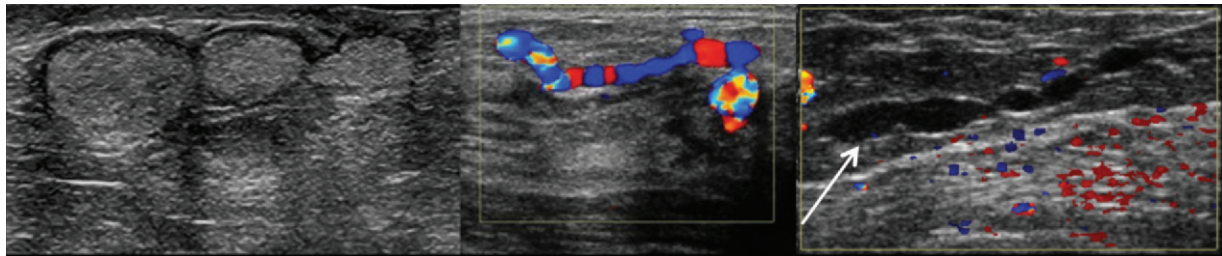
Special cases at US. Three new terms in the “special cases” category are shown: Gray-scale US image (left) shows fat necrosis, and color Doppler US images (center and right) show vascular abnormalities of arteriovenous malformations (center) and Mondor disease (right; arrow).
